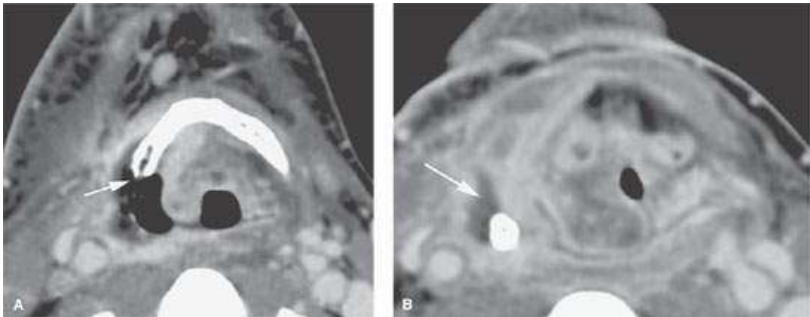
Patient treated with radiotherapy for a marginal supraglottic primary tumor. CECT study was done because of pain following therapy. A: There is a large gas and fluid filled cavity (arrow) surrounding the necrotic hyoid bone. B: This process continued all the way down the thyroid lamina mainly outside the larynx to surround the superior cornu of the thyroid cartilage (arrow) which articulates with the hyoid bone and a similar cavity filled with fluid, air and surrounded by extensive enhancing tissue was present. There was also significant laryngeal edema present. (Note: At this point, necrosis alone cannot be differentiated from necrosis with tumor. FDG PET would be unlikely to help in this circumstance since would almost certainly show the process to be hypermetabolic. The patient eventually came to laryngectomy. Only necrosis was found. The laryngectomy was done because the larynx had no functional use and the patient was in pain and aspirating.)
